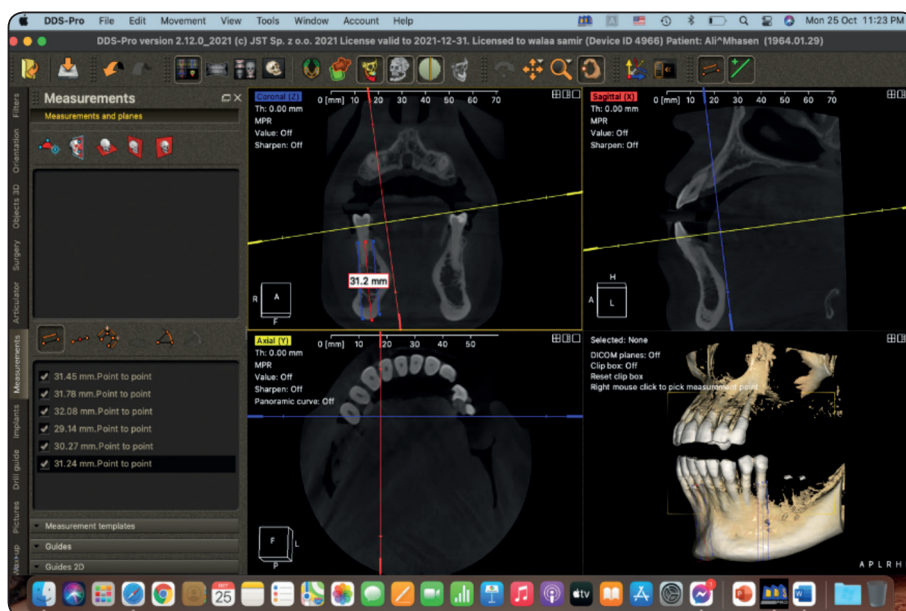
Bone measurements at abutment after adjustment of coronal and sagittal CBCT view on DDS-PRO software.
